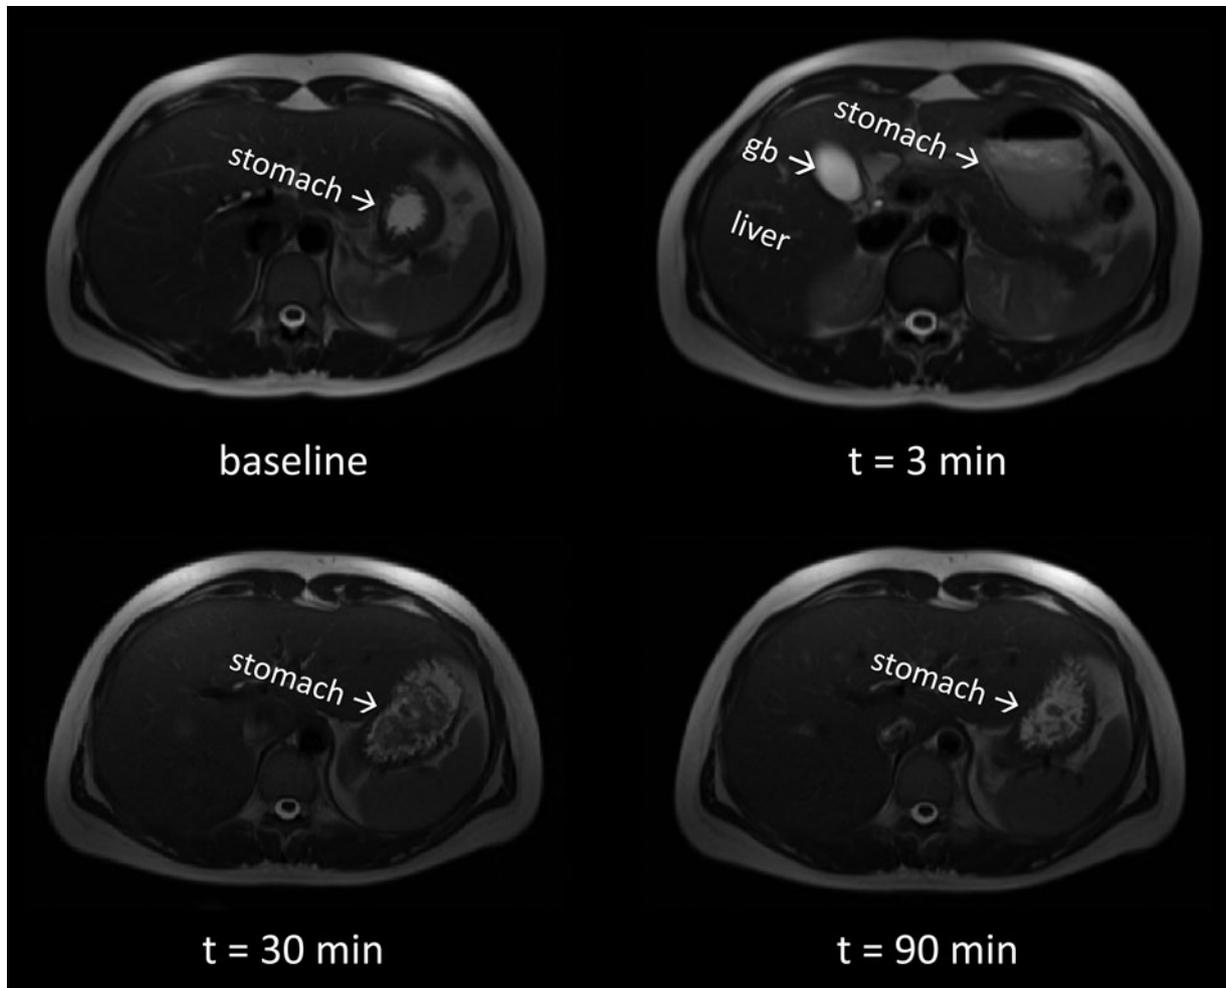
Examples of T_2 -weighted magnetic resonance images showing cross-sections through an empty stomach after an overnight fast (baseline) and after 250 ml milk consumption. At $t = 3$ min the gallbladder (gb) is clearly visible, and the gastric contents visible at baseline can be seen on top of the milk. At $t = 30$ and 90 min milk protein coagulation can be observed.
